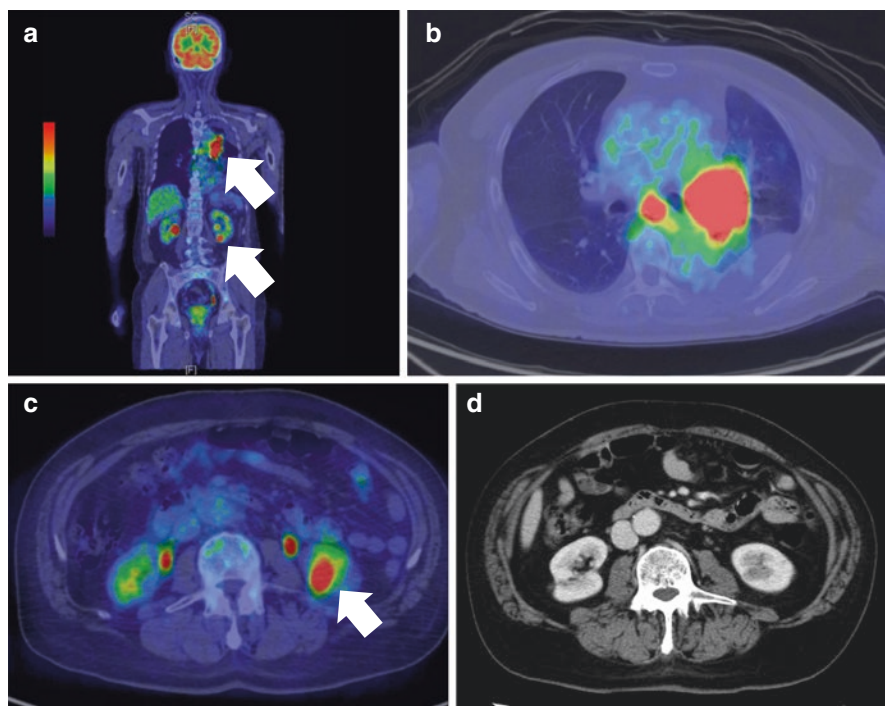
A 70s' male with surgically treated left lung cancer. (a) A postoperative FDG/PET fusion coronal section image indicates strong uptake in the chest and left kidney (arrows), suggesting recurrent tumors. (b) A chest FDG/PET fusion image shows strong uptake in the remaining left lung and mediastinum, compatible with recurrence. (c) An abdominal FDG/PET fusion image shows strong activity in the left kidney (arrow), indicating malignant tumor. (d) However, an abdominal contrast-enhanced CT image fails to clearly depict recurrence in the left kidney
